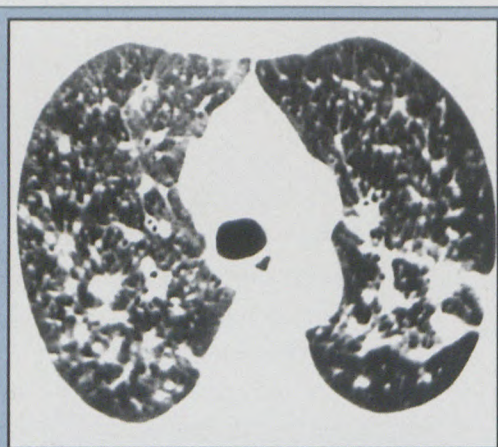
HRCT views of the lungs of the patient in 2a. A diffuse centrilobular distribution is seen with slight bronchial wall thickening. Irregular spiculated nodules of varying size are evident, some possibly representing bronchovascular markings. Interlobular lines are thickened.
